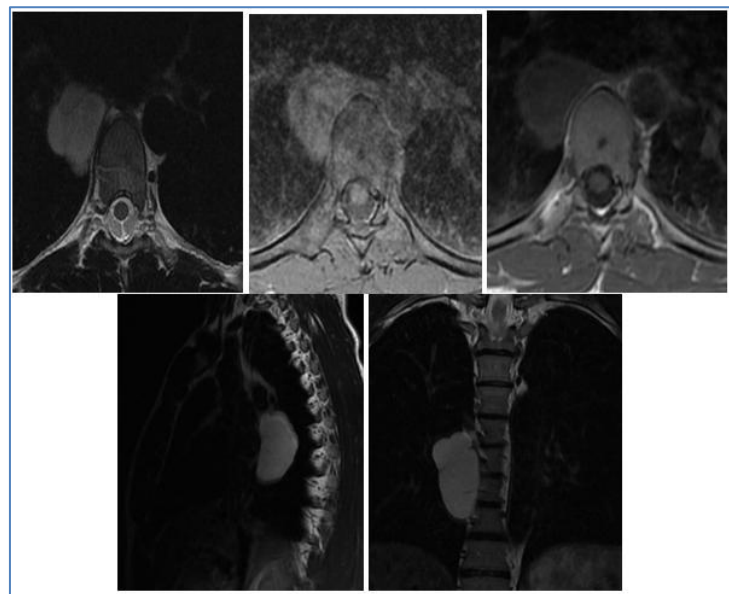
Thoracic spine MRI in axial, sagittal and coronal section showing the posterior mediastinum mass, with thin septations, discreet wall enhancement and no associated vertebral or medullary anomaly
